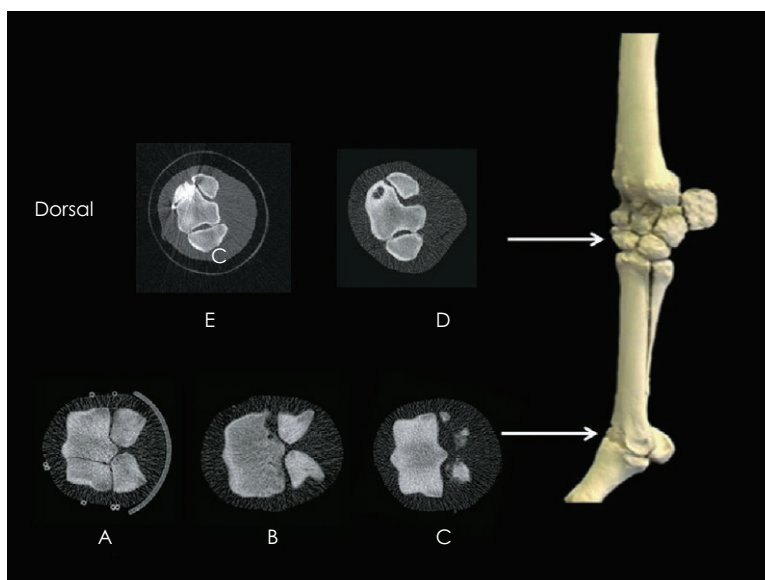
Cases where CT was performed to plan surgery and to confirm surgical result: (A) condylar fracture; (B) supracondylar lysis in palmar MC III; (C) fragmentation of distal aspect of proximal sesamoid bones; (D) osseous cyst-like lesion in third carpal bone; (E) sagittal fracture of third carpal bone treated by internal fixation. Note the artefact generated by the screw.
